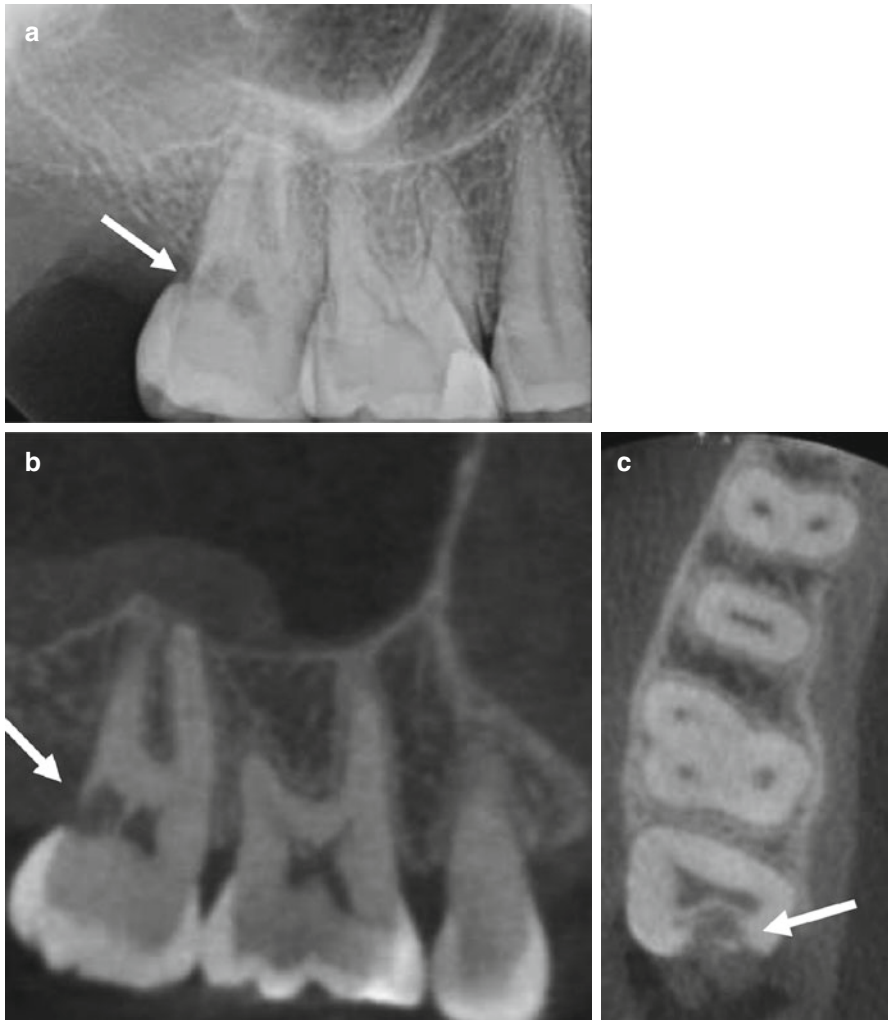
CBCT has been shown to be more accurate than periapical radiography in the detection of invasive cervical resorption. A 41-year-old female patient presented with a history of orthodontic treatment during childhood. (a) Periapical radiograph of the maxillary right second molar shows an irregular area of low density in the coronal third, with ill-defined margins and penetration into the dentin (*arrow*). CBCT images of the (b) sagittal reformation, and (c) axial reformation demonstrate the full extent of the resorptive defect including the portal of entry (*arrows*). The pulp space was preserved by the peritubular dentin and there is a moderate mucositis superior to the second molar. The tooth was deemed non-restorable and extraction was recommended. The acquired CBCT scan was used for implant site assessment
